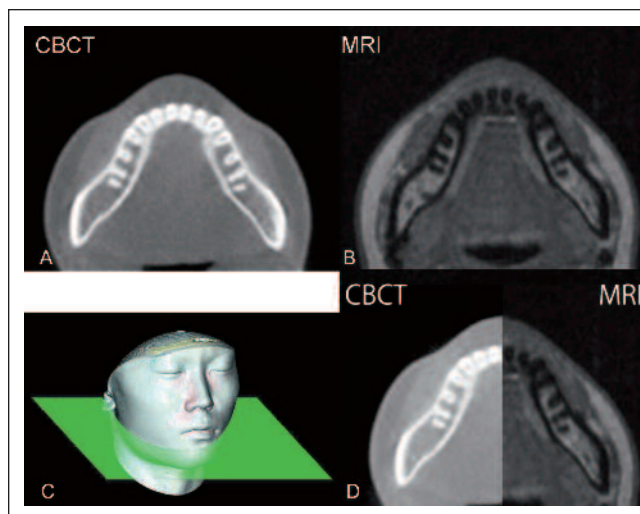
Two representative images of CBCT (A) and MRI (B). The combined MRI/CBCT images are obtained from the same cross-section (C and D).
